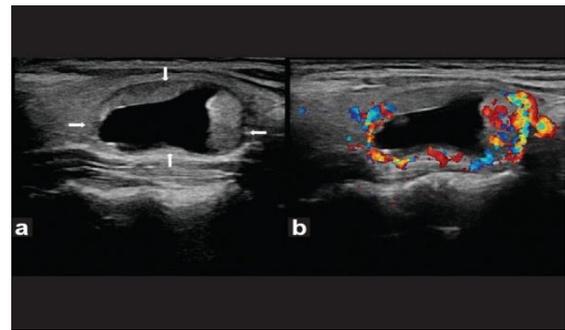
Transverse grey scale ultrasound and colour doppler show large intramural cyst s/o benign thyroid nodule.
